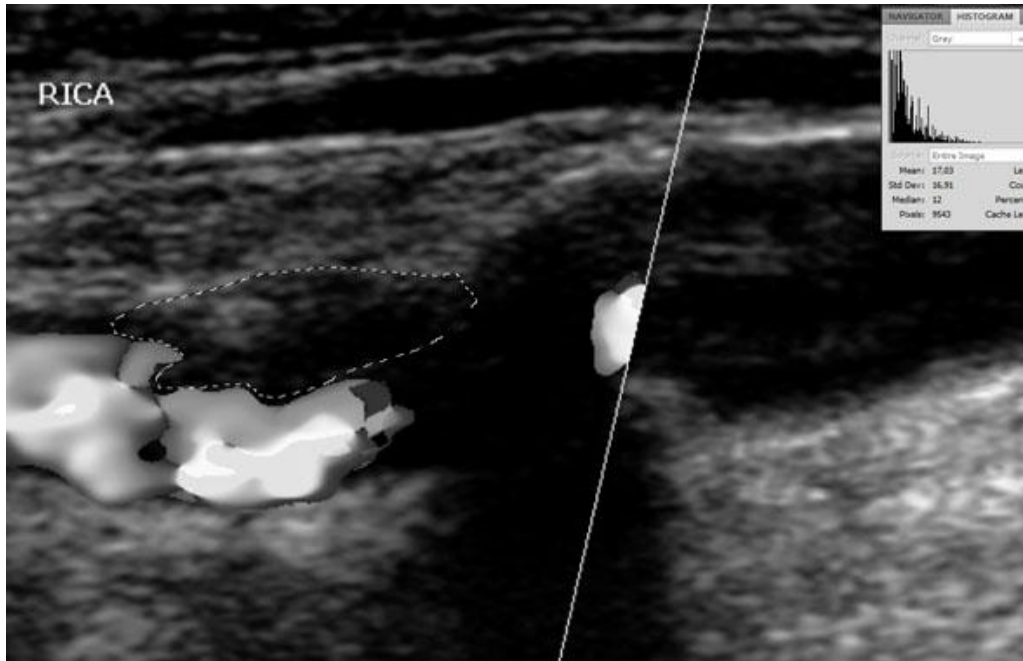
An example of internal carotid plaque selection and GSM calculation using Adobe Photoshop on a colour Doppler greyscale normalized image
